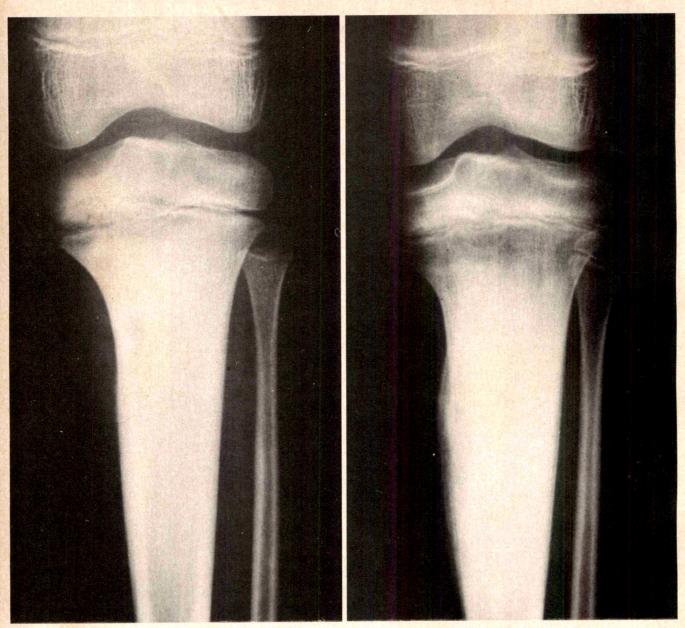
Left, Roentgenogram of left knee in patient 11, who had osteomyelitis of Garré. Osteolytic areas surrounded by diffuse sclerosis were present in tibial metaphysis. Right, Same lesion 18 months later. Periosteal reaction and intense sclerosis were present in metaphysis except for zone of new bone formation adjacent to epiphyseal plate.
